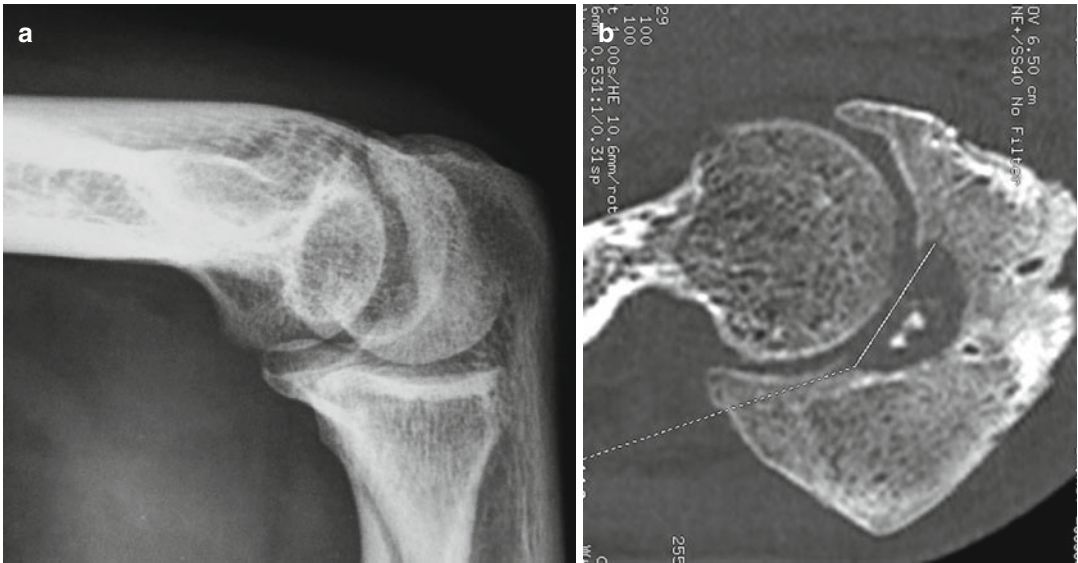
(a) Diagnosis can be made on plain radiography (a), but a computed tomography (CT) scan (b) and/or MRI is usually helpful. (b) Diagnosis can be made on
